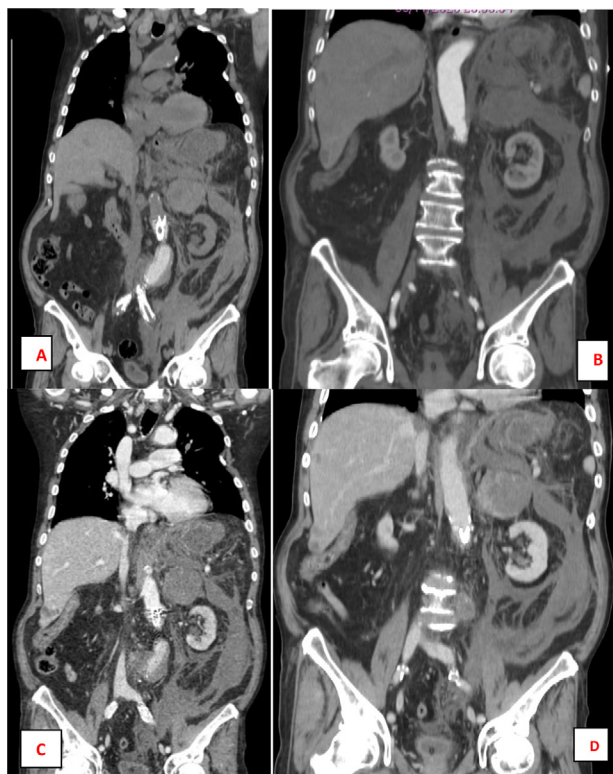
Coronal CT reconstructions well show the hemorrhagic left adrenal metastasis (8 cm), and also allow an overview of the extent of bleeding in the left abdominal quadrants, in the basal phase (A), arterial phase (B), portal phases (C), and in the late contrastographic study (D).
